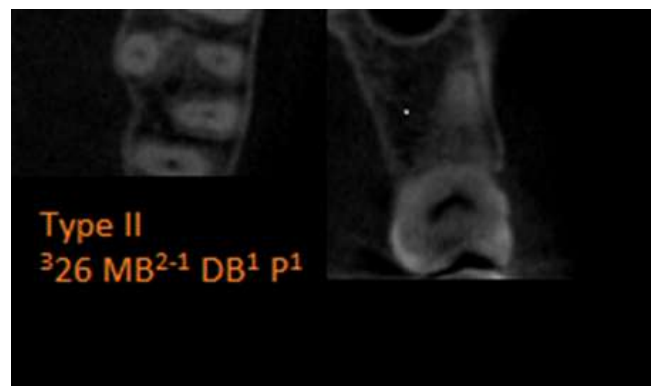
CBCT images demonstrating root canal morphological variations of three-rooted maxillary molar tooth using the two systems [above – Vertucci classification; below – new system (Ahmed et al. 2017)]; 26: Maxillary left first molar, MB: Mesiobuccal, DB: Distobuccal, P: Palatal.
